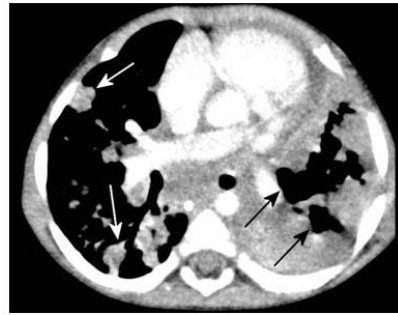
10-month-old boy with lymphobronchial TB. Contrast-enhanced axial chest CT demonstrates multiple cavities (*black arrows*) within the consolidated left lung. This was secondary to compression of the left main bronchus (not shown). There are subcarinal lymphadenopathy and multifocal soft-tissue nodules in the right lung (*white arrows*)
